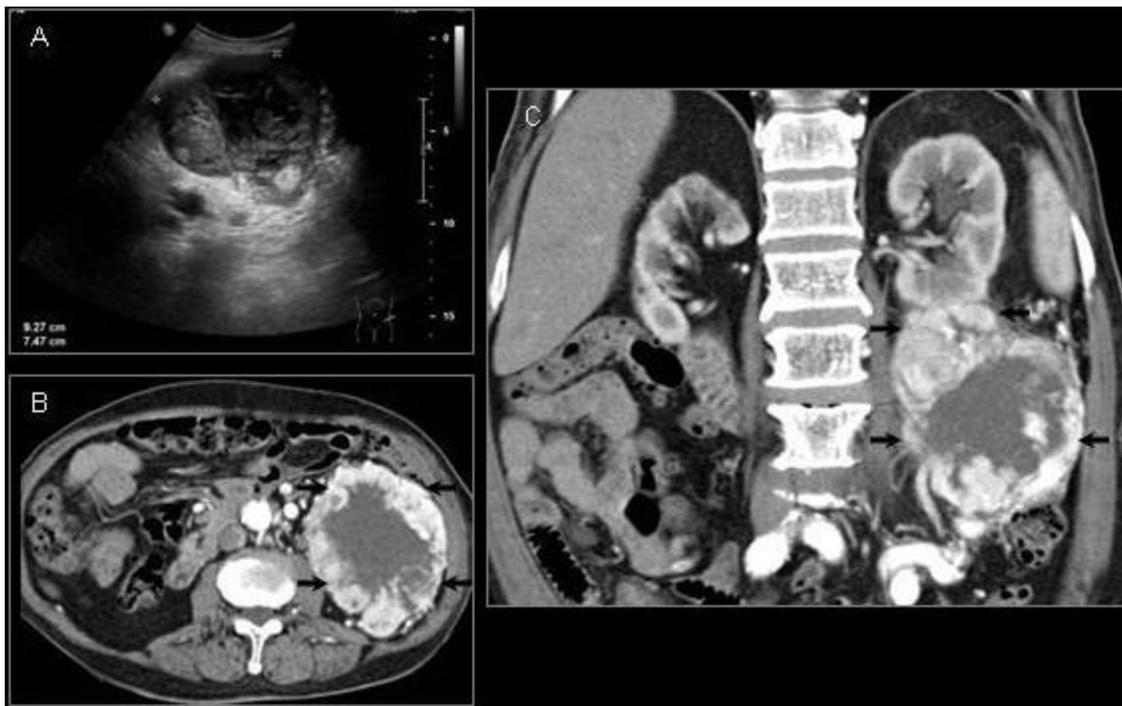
Left para-sagittal ultrasound image (A) showed large heterogenous tumour in the lower pole of left kidney. Contrast-enhanced CT scan of the abdomen in (B) axial plane and (C) coronal reformatted image showing a hypervascular left renal mass (black arrows) with necrotic centre and multiple parasitized arteries supplying the mass.
